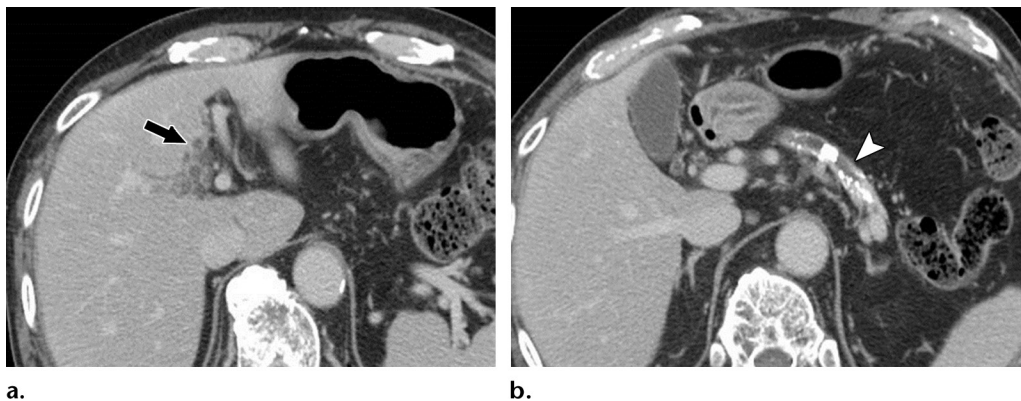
Simultaneous occurrence of peribiliary cysts (a) and chronic pancreatitis (b) in a 55-year-old alcoholic man. (a) Axial contrast-enhanced CT image depicts multiple small cysts (arrow) in the left perihilar area, a finding consistent with peribiliary cysts. (b) Axial contrast-enhanced CT image shows an atrophic pancreas with a dilated main pancreatic duct and calcifications (arrowhead), findings consistent with chronic pancreatitis.
